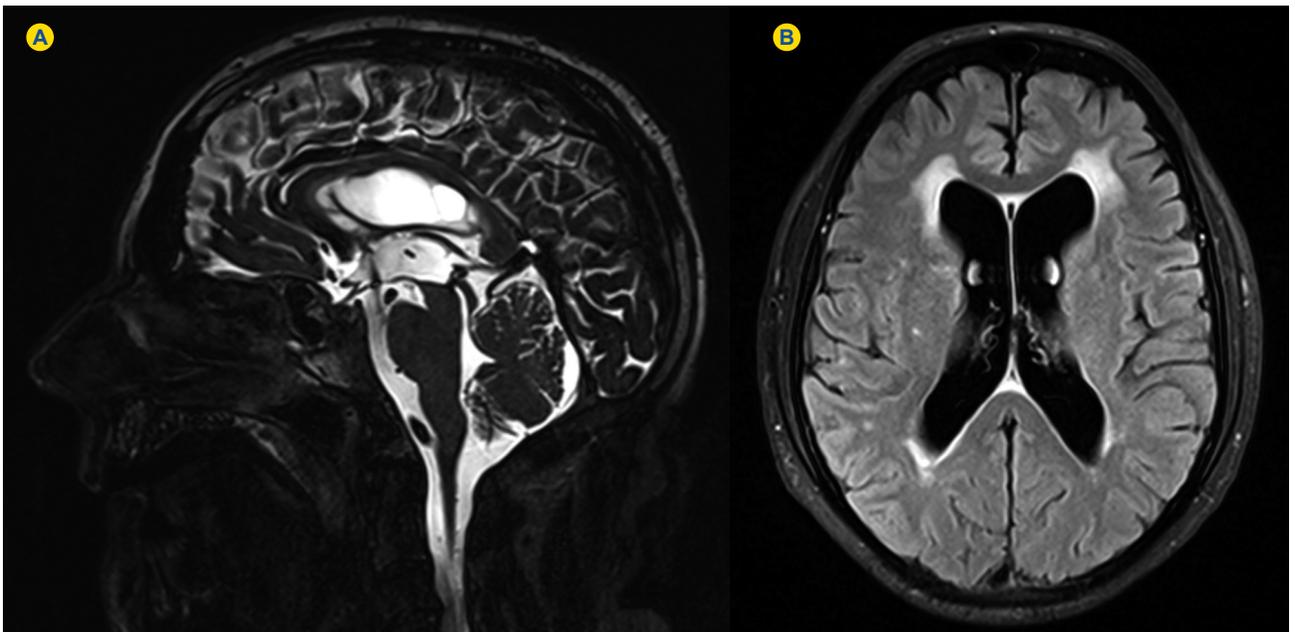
Post-operative MRI three weeks after neurosurgery. A, Sagittal 3D-CISS reconstruction. Linear flow-void sign crossing the floor of the third ventricle, consistent with patency of ventriculostomy; B, axial T2 FLAIR. Decrease of ventricular size and periventricular interstitial edema.
